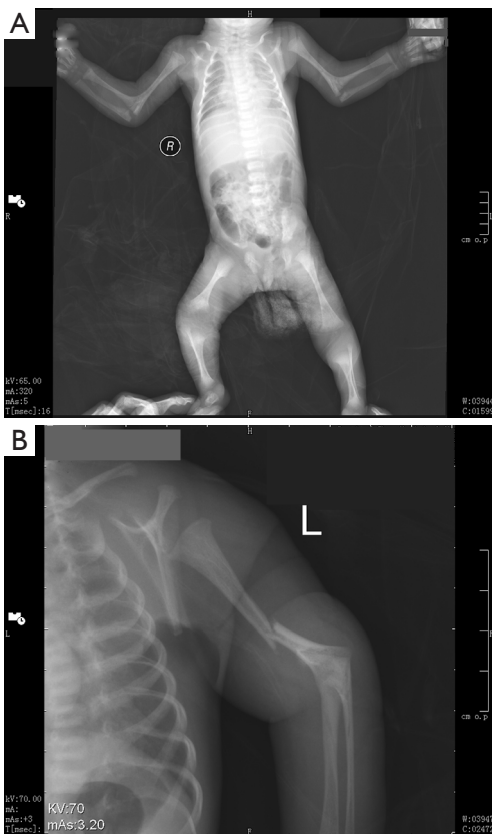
Bilateral femora deformation, radio-ulnar synostosis, femoral bowing and fractures, joint contractures, which were combined as limb malformations showing in this radiograph.
